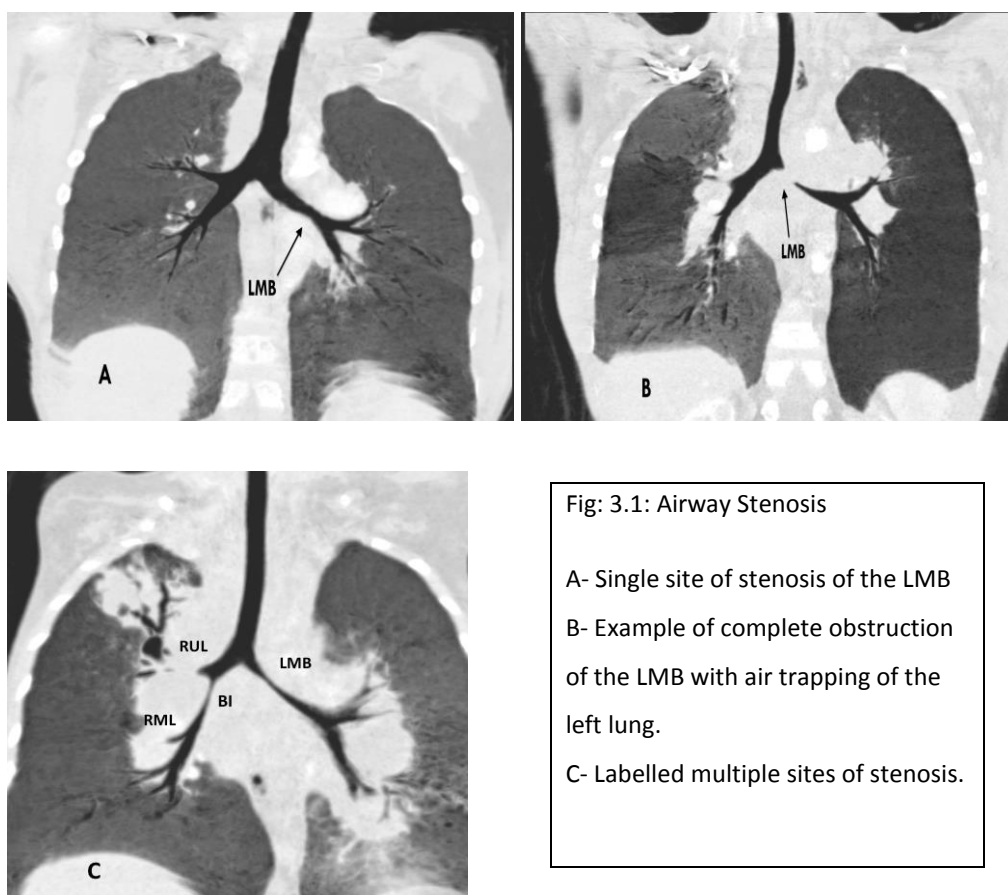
Examples of single and multiple airway stenoses (A, B, C) on coronal CT MinIP reconstructions
